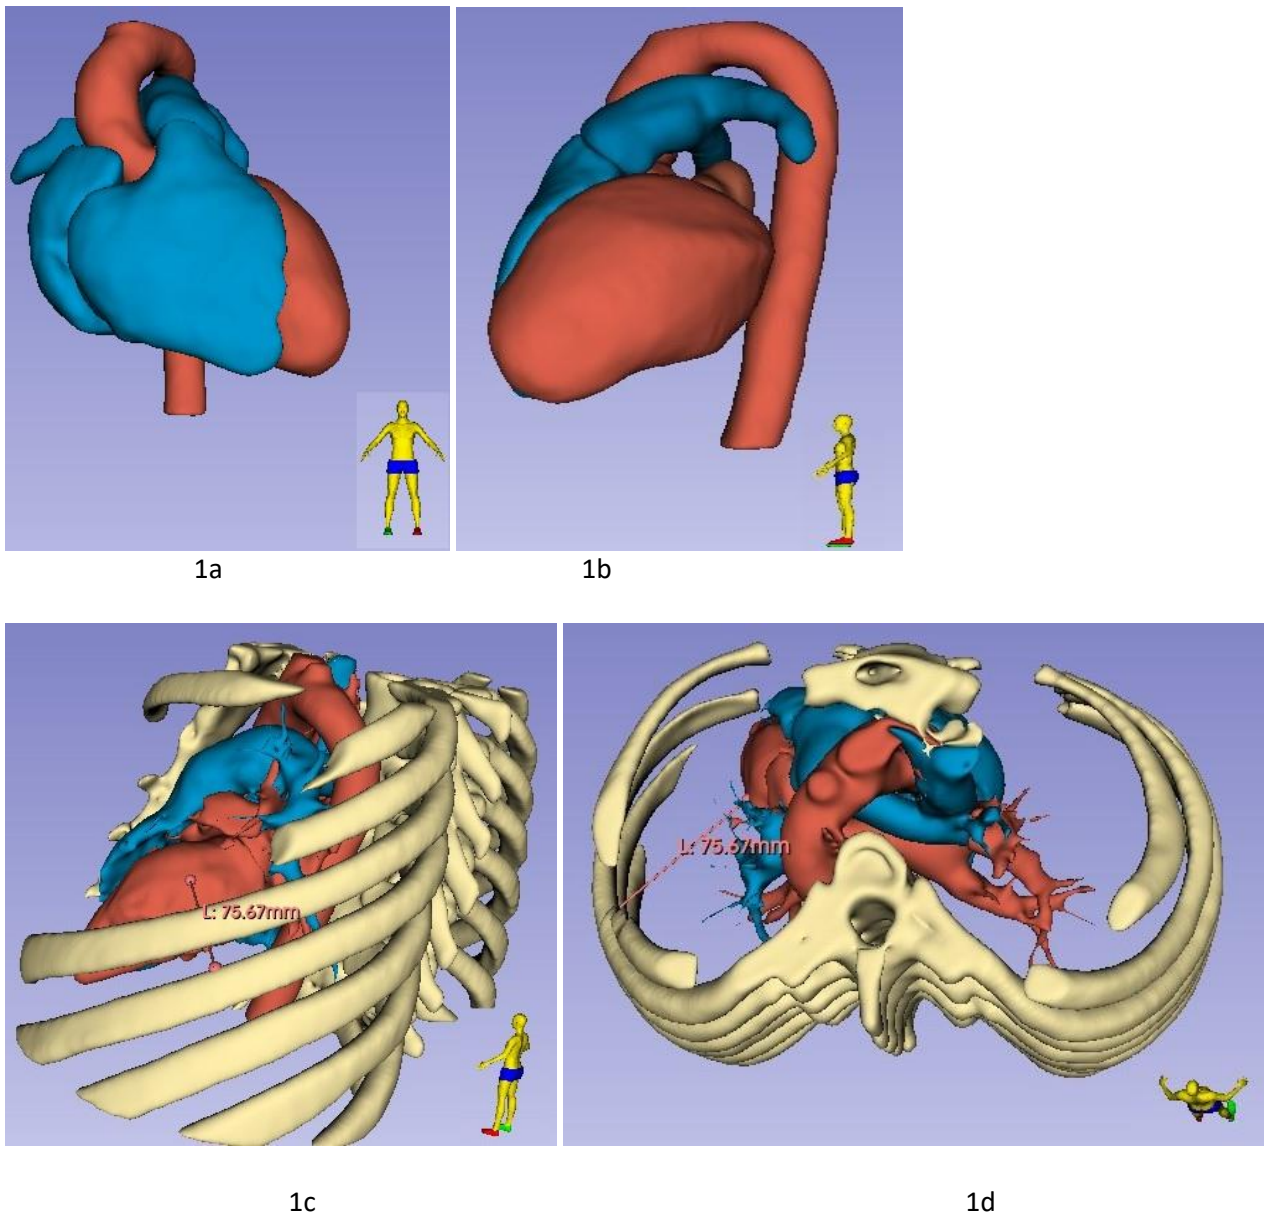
Computed tomography reconstruction of the heart (see explanations in the text)
